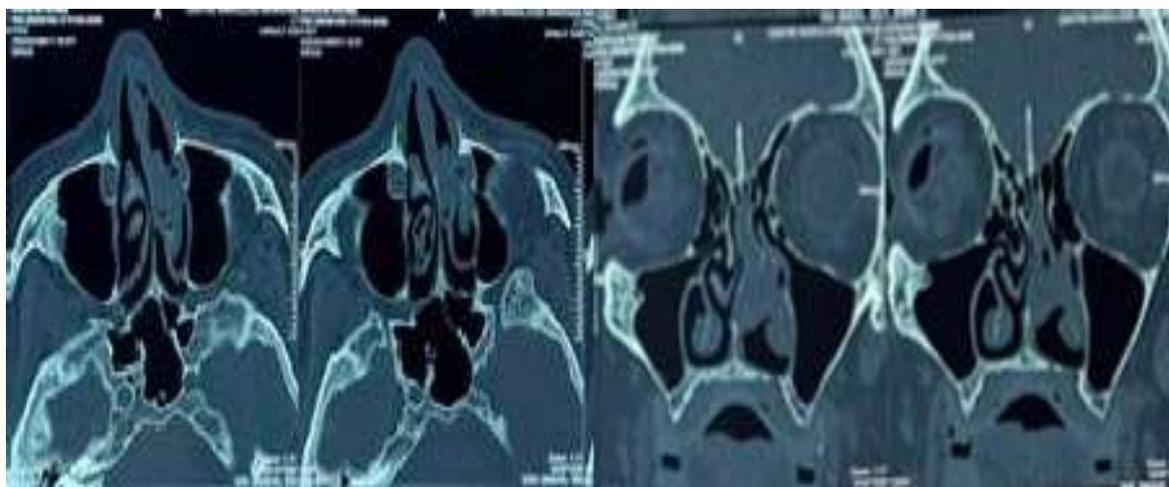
naso-sinusual CT-Scan: left ethmoid-nasal polypoid tissue
